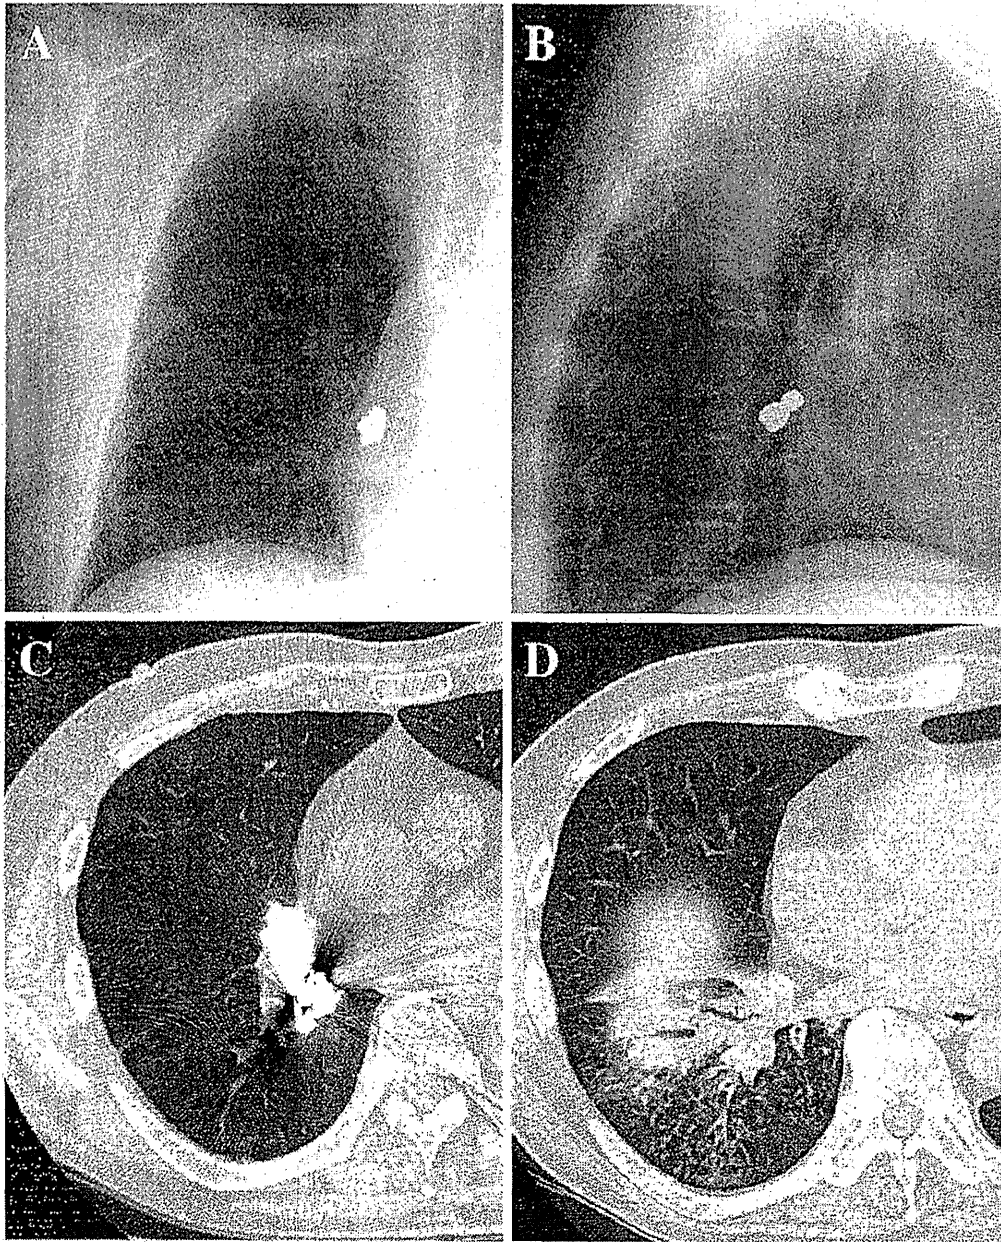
A, B: Chest radiography revealed a foreign body in the right lung field. C, D: Chest CT showed a metal crown in the right truncus intermedius that had induced atelectasis in the right lower lobe.
